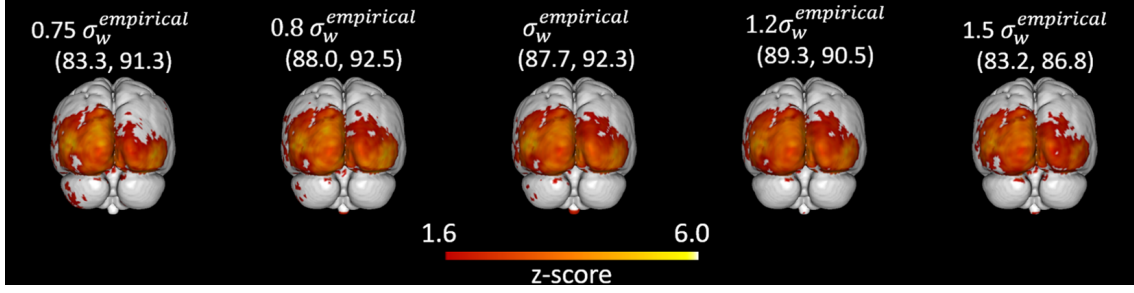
Effect of varying the weights-parameter  $\sigma_w$  for MRI-MRF prior. Analysis of the effect of varying  $\sigma_w$  around the empirically chosen value  $\sigma_w^{\text{empirical}}$  on the activation maps for the MRI-MRF method. The values in the parenthesis represent the sensitivity and specificity values obtained for the component corresponding to the visual task from the ICA respectively.
